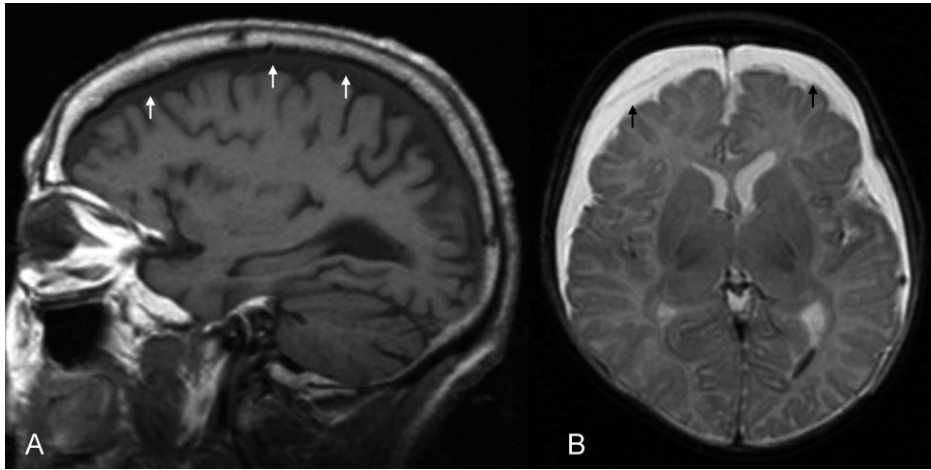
Appearance of the chronic subdural hematoma on magnetic resonance imaging. The chronic subdural hematoma is always slightly higher in signal intensity than cerebrospinal fluid on T1-weighted and T2-weighted images. It is (A) hypointense to gray and white matter on T1-weighted images (arrows) and (B) hyperintense to brain parenchyma on T2-weighted images. Unlike prominent subarachnoid spaces that are characteristic of cerebral atrophy, the chronic subdural hematoma causes effacement of the sulci. In addition, when rebleeding has occurred, septations may be identified within the collection (arrows).
